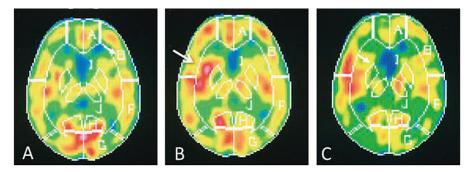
Representative case of adult-onset moyamoya disease manifesting as focal cerebral hyperperfusion. N-isopropyl-p-[<sup>123</sup>I] iodoamphetamine single-photon emission computed tomography before (A) and one day (B), and seven days (C) after right STA-MCA anastomosis demonstrating marked increase in CBF near the site of the anastomosis (arrow in B) compared to pre-operative status (A). Focal hyperperfusion was ameliorated 7 days after surgery (C).
